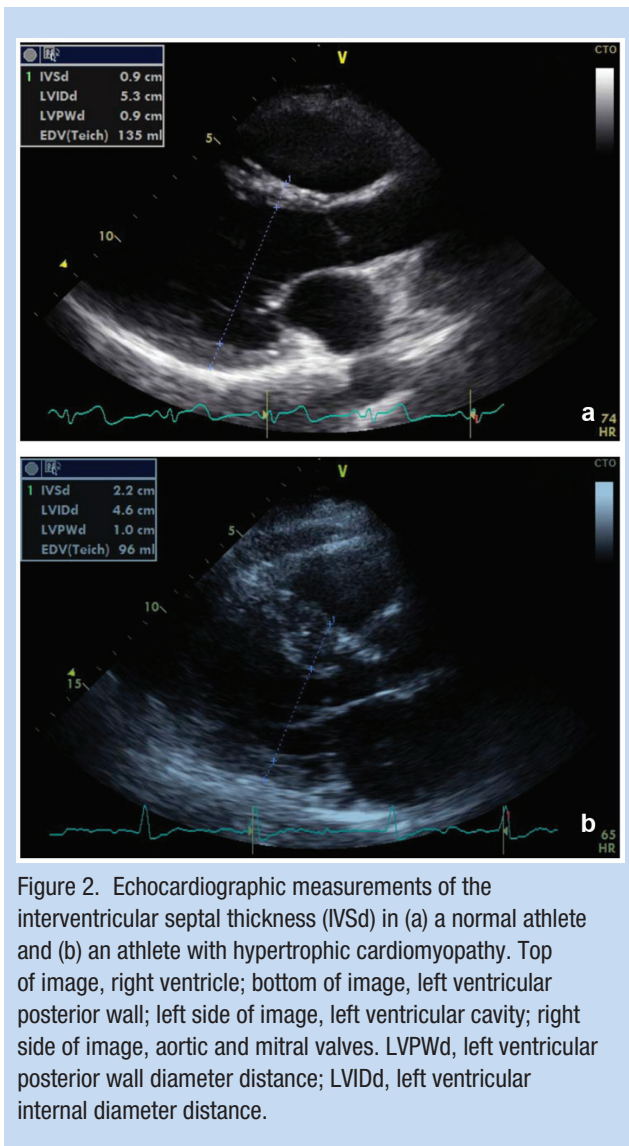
Echocardiographic measurements of the interventricular septal thickness (IVSd) in (a) a normal athlete and (b) an athlete with hypertrophic cardiomyopathy. Top of image, right ventricle; bottom of image, left ventricular posterior wall; left side of image, left ventricular cavity; right side of image, aortic and mitral valves. LVPWd, left ventricular posterior wall diameter distance; LVIDd, left ventricular internal diameter distance.
